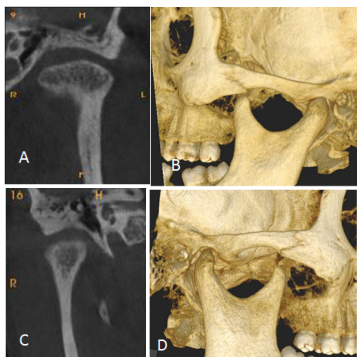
A & B): CBCT image of Left condyle with splint in maximum intercuspation. Head of the condyle positioned center of glenoid fossa. C & D): CBCT image of Right condyle with splint in maximum intercuspation. Head of the condyle positioned center of glenoid fossa.
